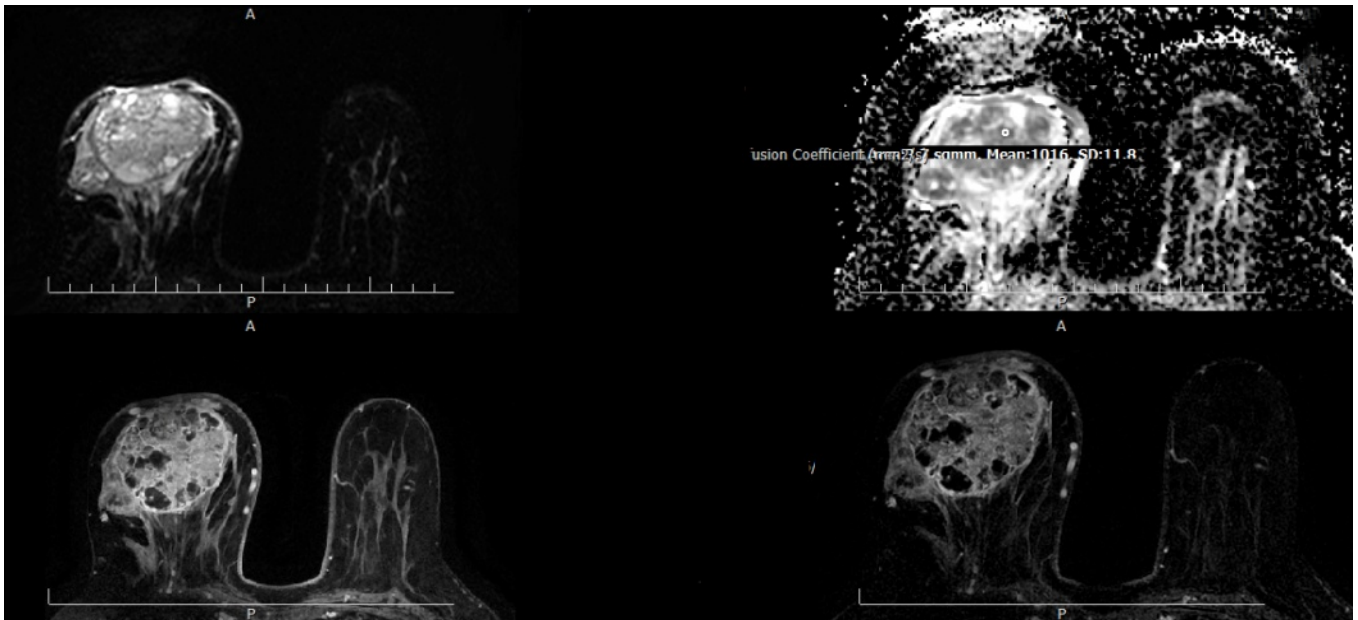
MRI Scans of Breast Lesions: The image displays a series of breast MRI scans organized in four panels. Top Left Panel: DWI-Top Right Panel: Apparent Diffusion Coefficient (ADC) map-Bottom Left Panel: dynamic image-Bottom Right Panel: subtract image. These images collectively assist in the evaluation and diagnosis of breast lesions.
